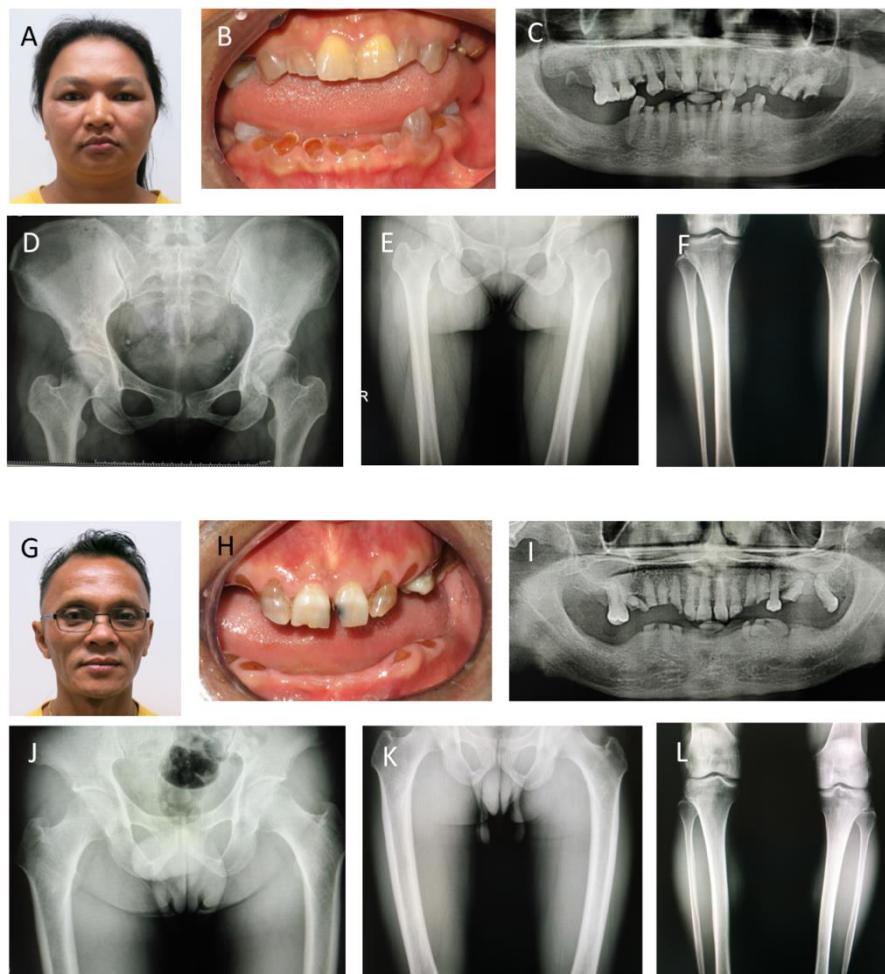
Clinical features associated with mother and father of proband. The photographs and radiographs display the clinical phenotype of mother (A-F) and father (G-L).
